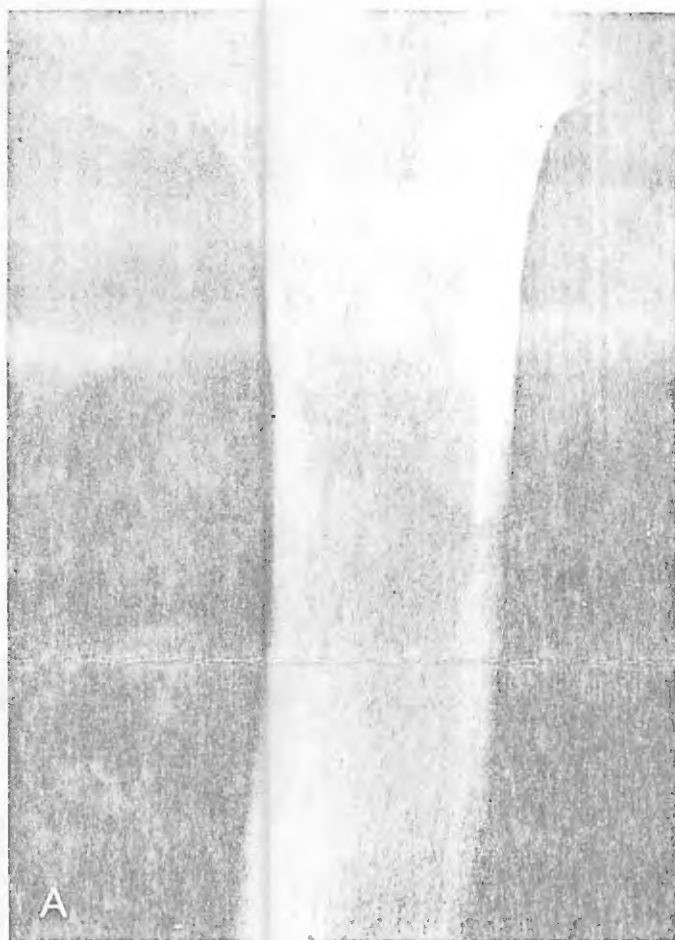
A: Acute calcific tendinitis of the gluteus maximus referred as suspected chondrosarcoma. B: Two days later, this radiograph shows typical fragmentation and partial resorption of the calcification. A later follow-up radiograph showed complete resorption of the calcific deposit.
